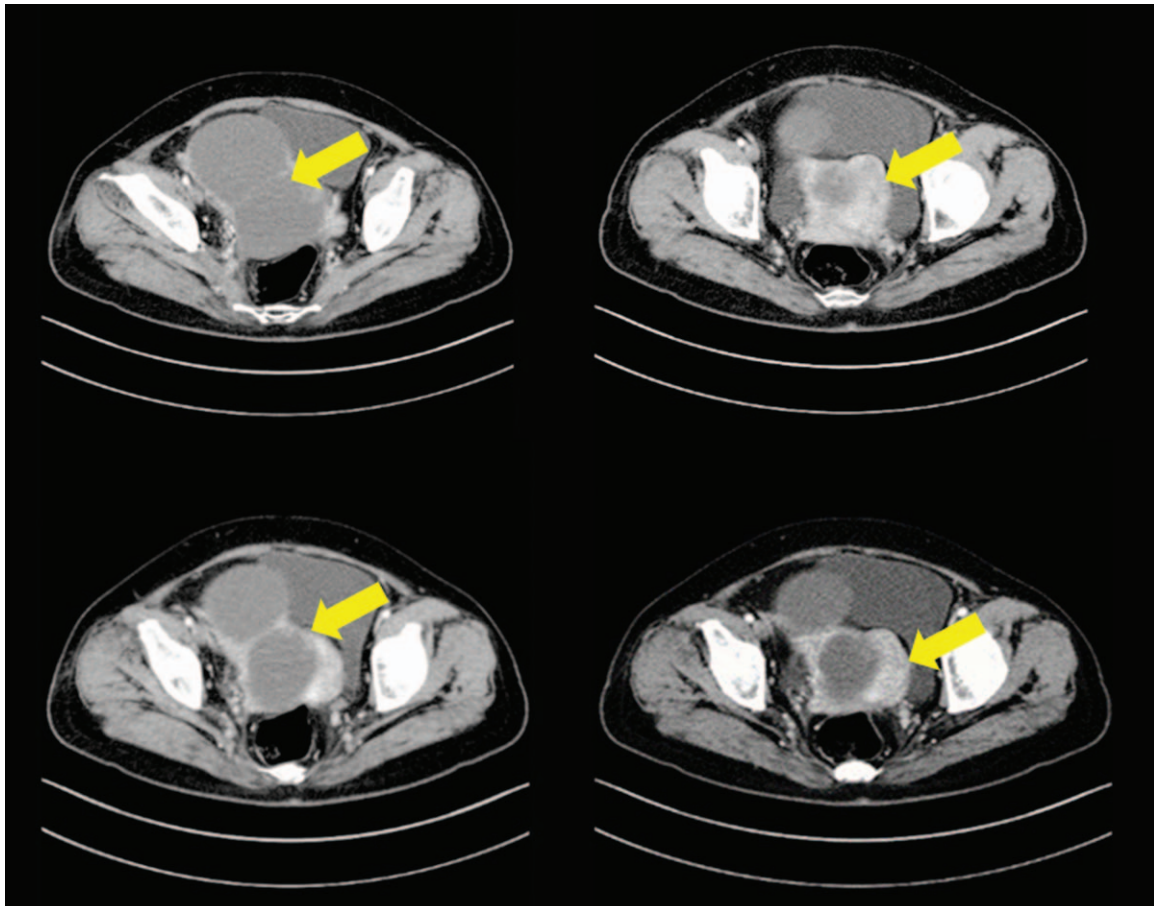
Case 2: Preoperative computed tomography images.
